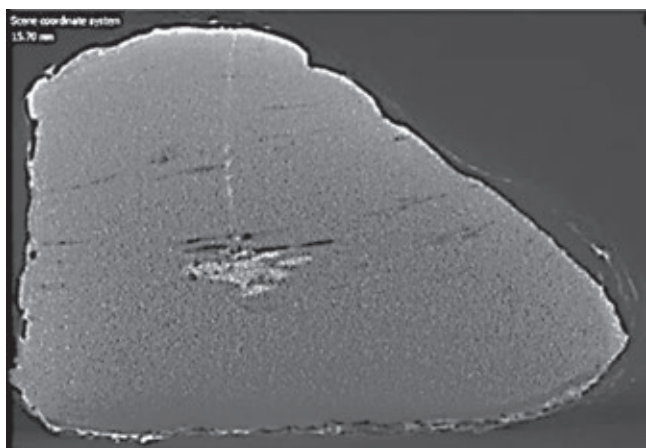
CT scan for bolus shape and size.
